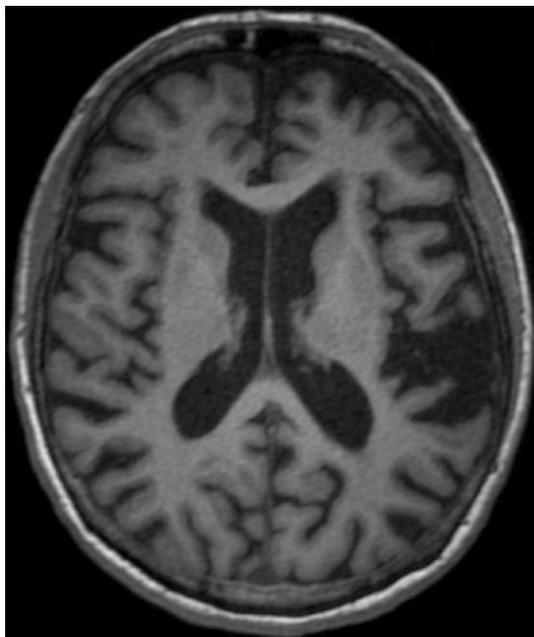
T1-MRI (*axial view*). Note extensive atrophy of anterior perisylvian areas on the left relative to the right
